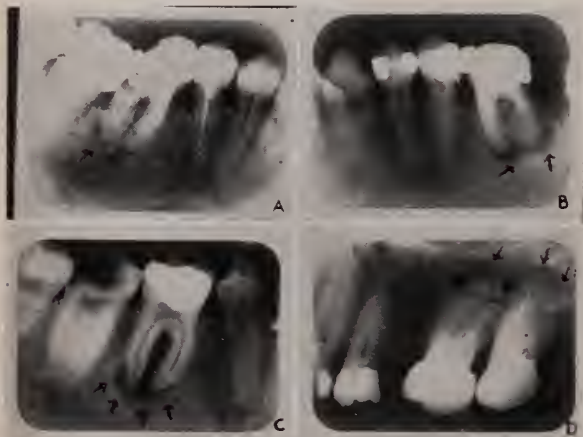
Roentgenograms showing chronic periapical infection about pulpless and devitalized teeth.
